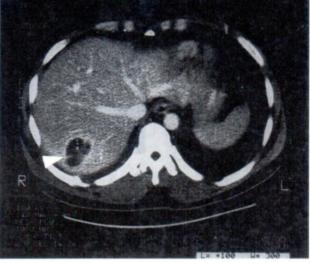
Liver injury grade II. There is contusional hematoma at posterior segment of right lobe liver. (arrow)A The patient underwent conservative treatment and follow up CT scan shows resolved hematoma.(arrow) B.
